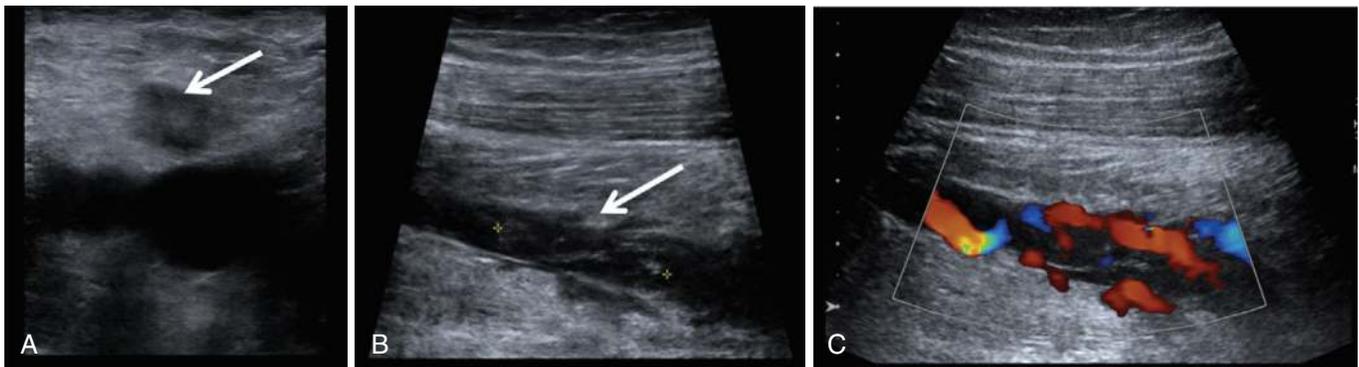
Occlusive (A) and nonocclusive (B) deep vein thrombus (arrows) on compression ultrasound. Doppler ultrasound confirms nonocclusive nature of thrombus (C).
